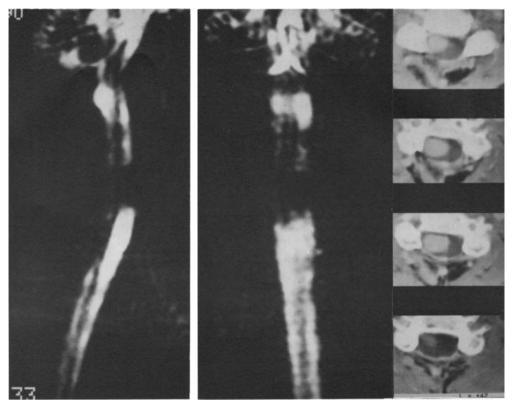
Cervical meningioma. RARE scans in lateral and frontal views and corresponding CT scans
